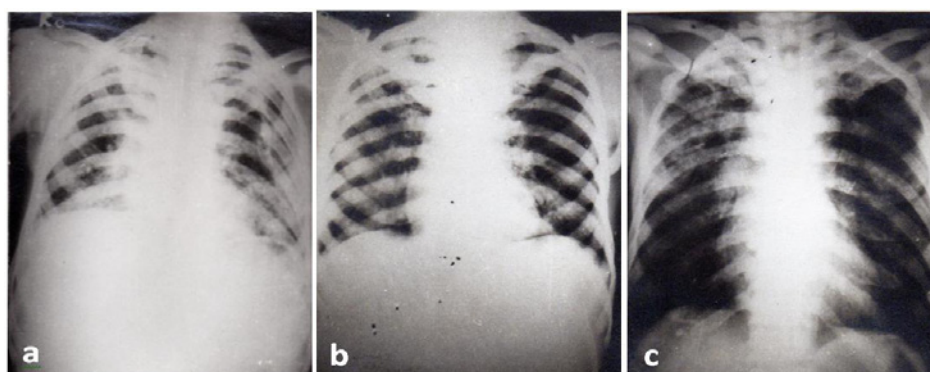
Radiographs of chests of subjects having mild (a), moderate (b), and severe (c) skeletal fluorosis showing a peculiar contrast between the chalky-white bony cage and translucent lungs, irregular thickening of ribs and clavicles, and calcification of muscles.
